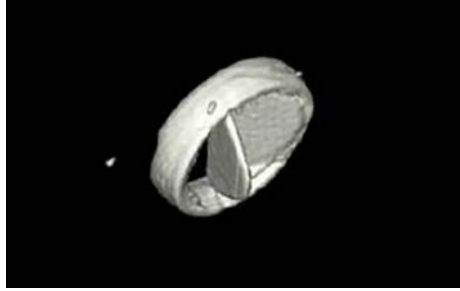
Non-contrast enhanced CT of a patient with a metallic aortic valve shown during systole. The leaflet in the right upper portion of the image is frozen in a closed position. This causes an increased transvalvular gradient, which can be measured by Doppler echocardiography.
